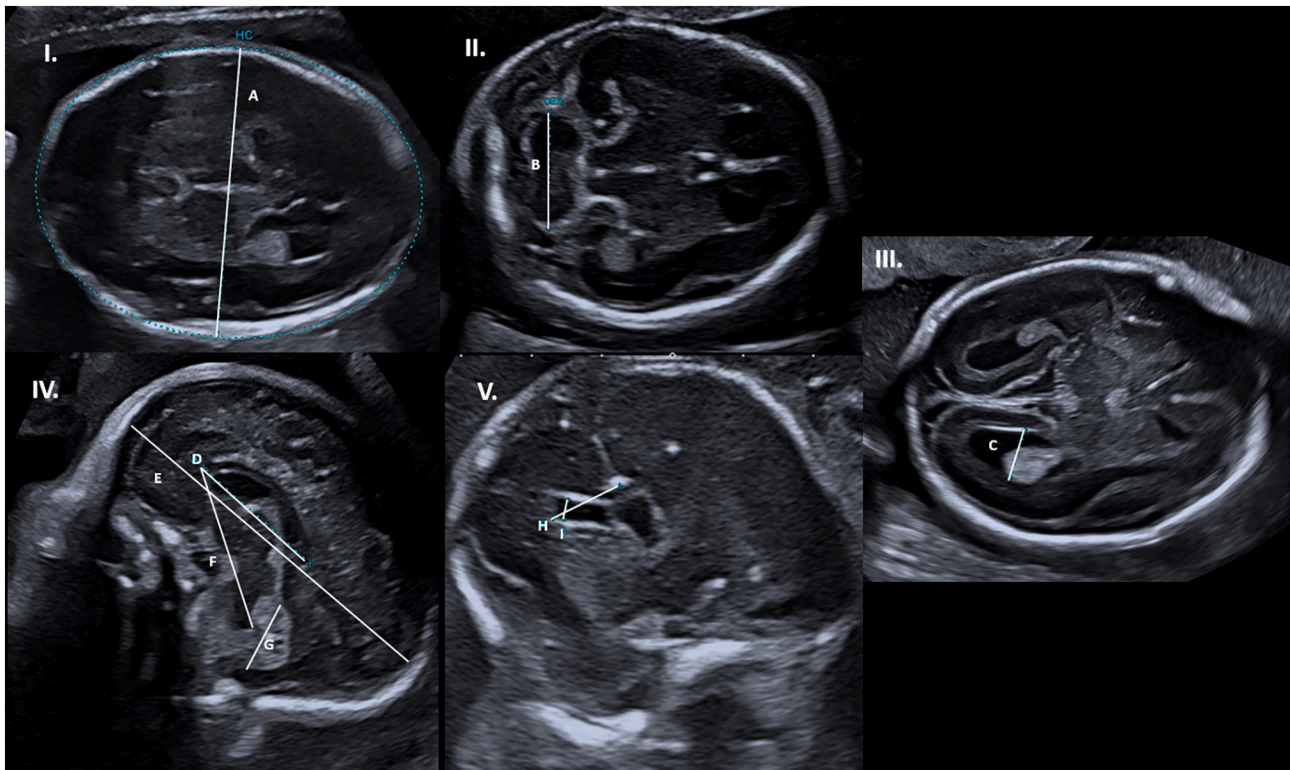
Recommended prenatal ultrasound measurements.
